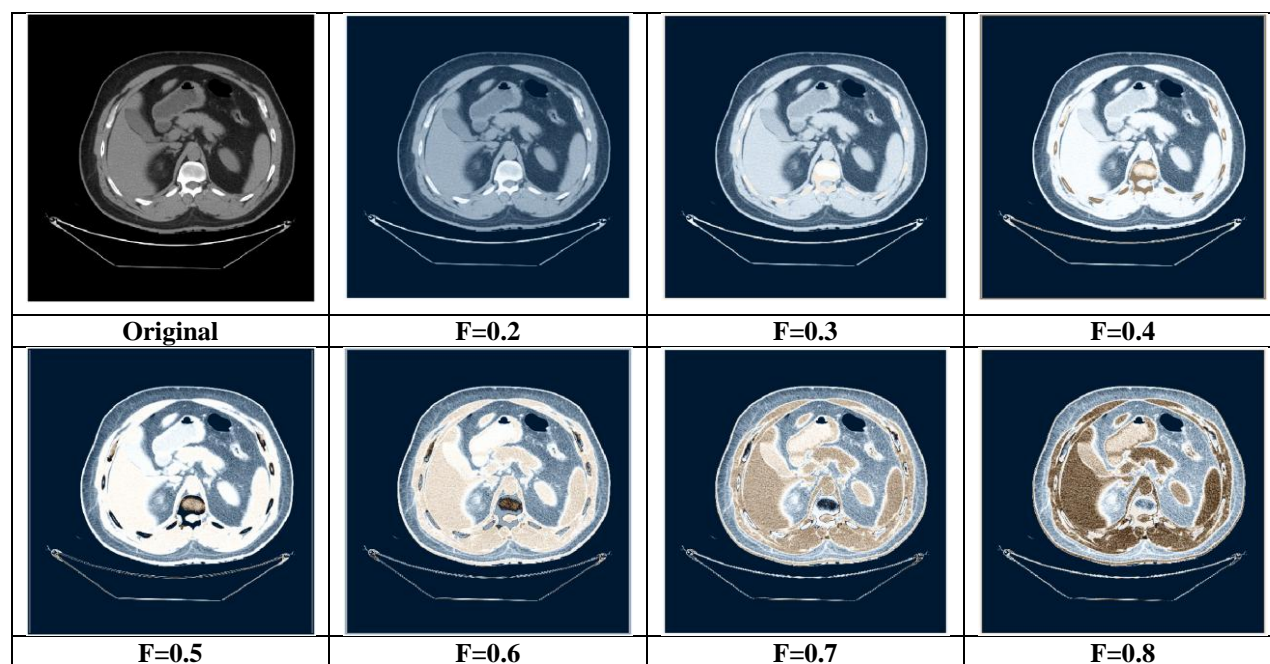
The color output CT-Scan images with different F values
